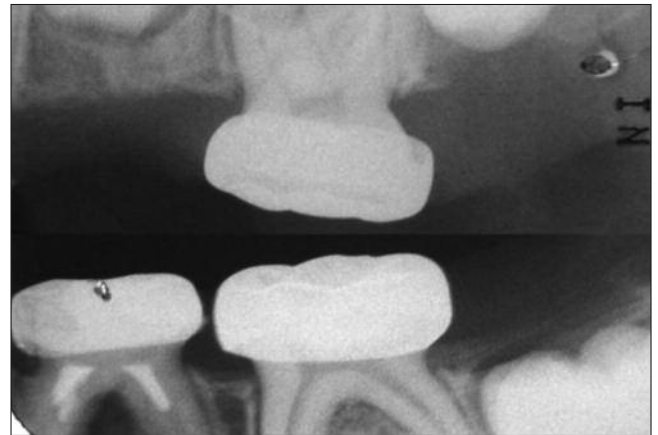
Bitewing radiograph of the left side
